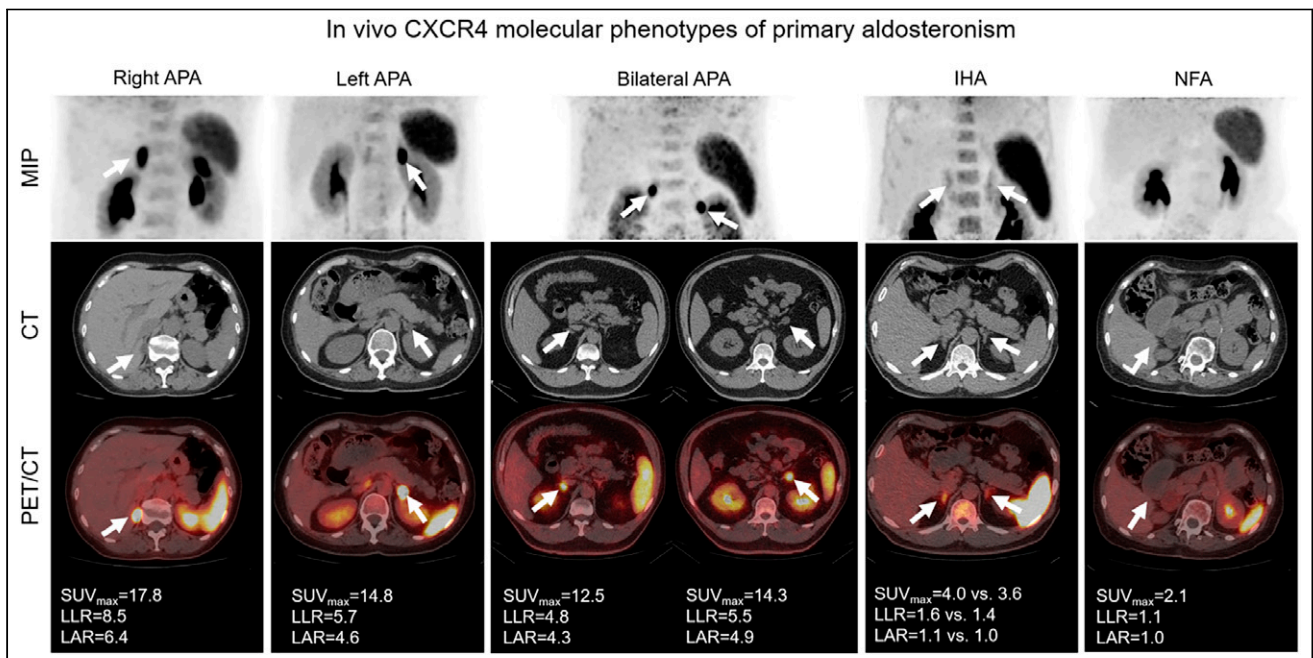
Representative CXCR4 PET/CT imaging of major forms of PA. IHA = idiopathic hyperaldosteronism; LAR = lesion-to-adrenal ratio; LLR = lesion-to-liver ratio; MIP = maximum-intensity projection; NFA = nonfunctional adenoma.
